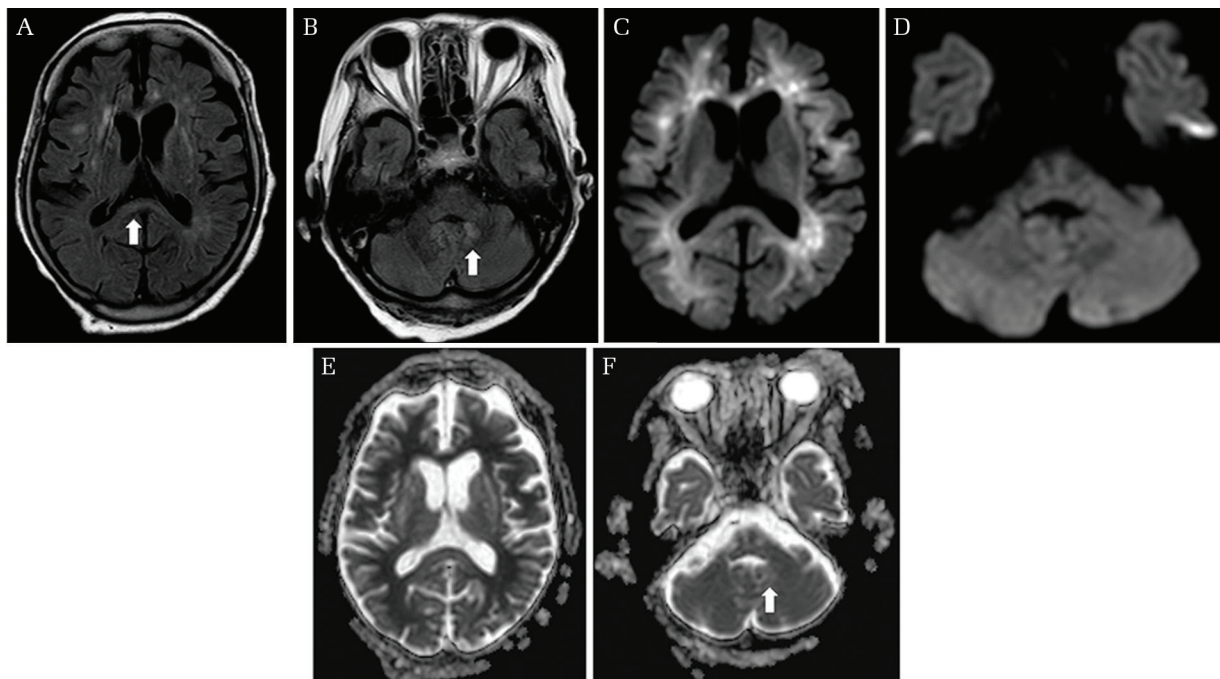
MRIs 20 hours after the onset. MRI Axial fluid attenuated inversion recovery (FLAIR) (A and B), diffusion weighted image (DWI) (C and D), apparent diffusion coefficient (ADC) map (E and F). (A) FLAIR image demonstrating the hyperintensity in the splenium of the corpus callosum (*arrow*). (B) FLAIR image showing the hyperintensities in the bilateral dentate nuclei. Stronger hyperintensity revealed in the left dentate nucleus (*arrow*) than in the right dentate nucleus. (C) DWI showing the hyperintensity areas in the bilateral deep white matter. The hyperintensity in the left white matter was seen especially in the frontal and the parieto-occipital regions. (D) DWI showing no remarkable change in the dentate nuclei. (E) ADC map demonstrating the isointensity area in the splenium of the corpus callosum. (F) ADC map demonstrating dominantly the hyperintensity area in the left dentate nucleus (*arrow*).
